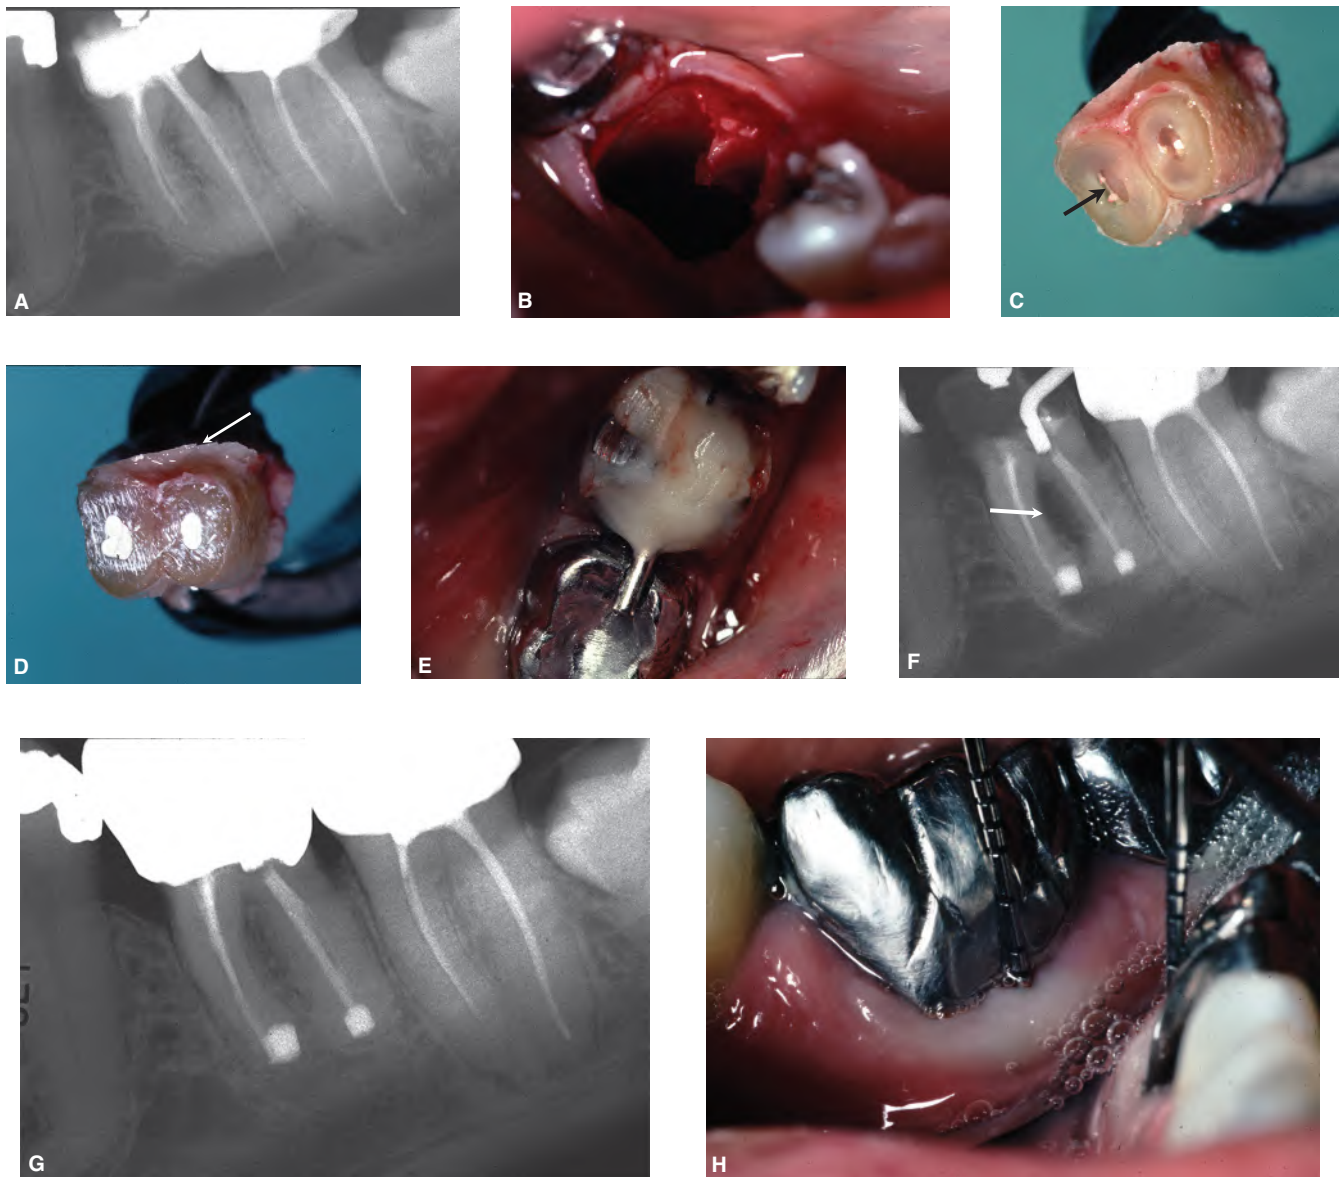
Intentional replantation in mandibular left first molar with dysethesia following root canal treatment. A. Preoperative radiograph. Evidence of over-instrumentation/overfilling in the distal canal, and underfilling/blockage in the mesial canals. The patient has had dysethesia since the completion of the RCT, and the apices may be in contact with the mandibular canal (radiographically). Conventional apical surgery is very risky, and may result in a permanent neurological deficit. B. During the extraction, a “snap” was heard. The tooth was delivered in whole, with no evidence of root fracture. Examination of the socket revealed that the buccal cortical plate fractured from the furcation, and was retained on the surface of the extracted tooth. The lingual portion of the plate will function as an index for the replanted tooth. C. Root-end resection and preparation has been completed. Note the isthmus between the MB and ML canals in the mesial root (arrow). D. Root-end fillings (Zinc Oxide Eugenol) in the mesial and distal root-end preparations. The buccal plate (arrow) inhibited replantation and was removed. The tooth will now require rigid splinting. E. The tooth has been replanted, and an orthodontic wire is secured in the access space, bent to index with the mesial marginal ridge of adjacent second molar. This will prevent a buccal luxation of the tooth, and the lingual index of bone prevents an occlusal displacement from the socket. F. Immediate postreplantation radiograph. The tooth is reduced in the alveolus to the correct depth, and will remain splinted for four to five weeks. Note the radiolucent area in the furcation corresponding to the loss of the buccal cortical plate (arrow). G. Eight-year recall radiograph. The bone has reformed in the furcation, and crowns have been placed on the first and second molars. The dysethesia resolved within three weeks, and normal sensation returned within six months. The patient is asymptomatic despite the poor endodontic treatment in the second molar; the patient declines any retreatment of the tooth, electing instead to have the IR done in case it becomes symptomatic. H. Periodontal probing depth of the buccal sulcus at an eight-year recall visit; 1.5 mm depth recorded in the furcation where the cortical plate was lost, indicative of regeneration of the plate.
